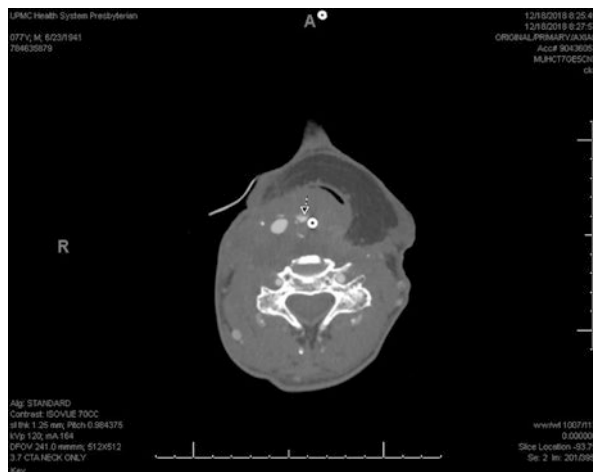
CT neck angiogram showing deep soft tissue emphysema with concern for dehiscence of the soft tissue anterior to the previously stented left common carotid artery
